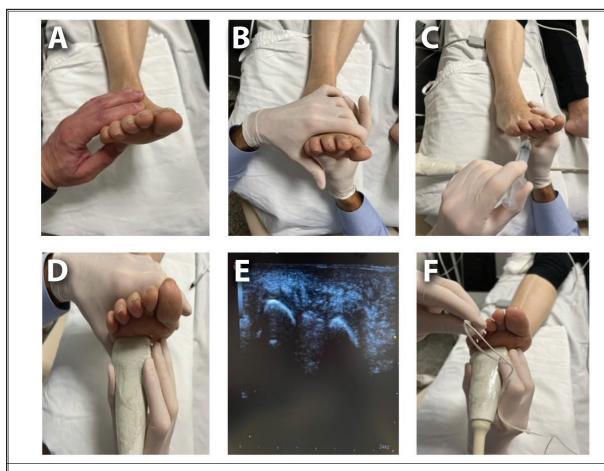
Intervention steps with PR in foot affected by Morton's neuroma. A) The patient's positioning. B) Mulder's test being applied. C) Application of anesthesia after the neuroma was located by ultrasound. D) Short axis of the ultrasound to better localize the intermetatarsal space. E) Plantar view of the transverse axis at the height of the metatarsal heads, with access to the interdigital space. F) The cannula was precisely placed at the edges of the neuroma (2 distinct points) "out of the plane." The positions were confirmed in the long axis of the foot "in the plane" (not represented).
